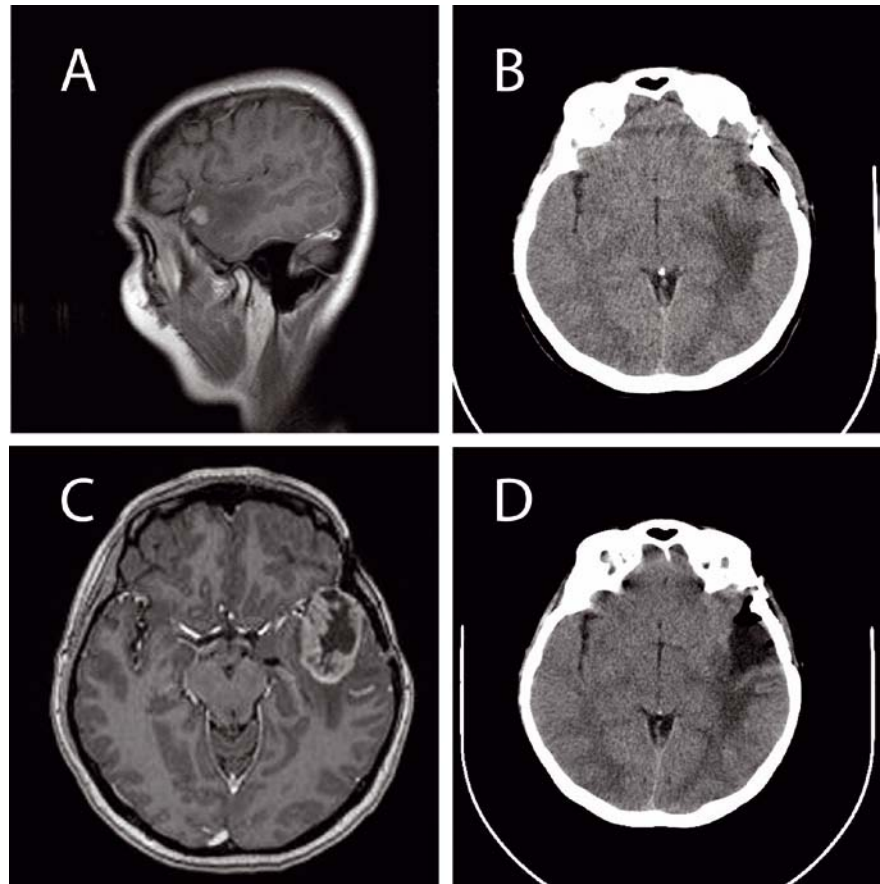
Preoperative magnetic resonance (MR) of the brain. Post-contrast coronal T1-weighted image showing a round tumorous lesion measuring 14x10 mm in the left superior temporal gyrus with surrounding brain edema involving the left superior and middle temporal gyrus. There is a homogenous post-contrast enhancement of a lesion (A). Multi-sliced computed tomography (MSCT) of the brain. Early postoperative native axial image showing the resected area left with no signs of residual tumor. There is an edema of the left temporal and insular area of the brain (B). MR of the brain. Post-contrast axial image showing a tumorous lesion of the left temporal region measuring 4x3 cm. Contrast enhancement of the lesion is inhomogenous with central hypointense necrotic part and peripheral hyperintense ring. There is a marked difference in the appearance of the lesion in comparison with preoperative MR of the brain (C). MSCT of the brain. Postoperative native axial image. The resected area left temporal is now larger, showing no signs of hemorrhage nor of residual tumor. There is a small quantity of air in the operative field and an edema of the left temporal and insular area (D).
